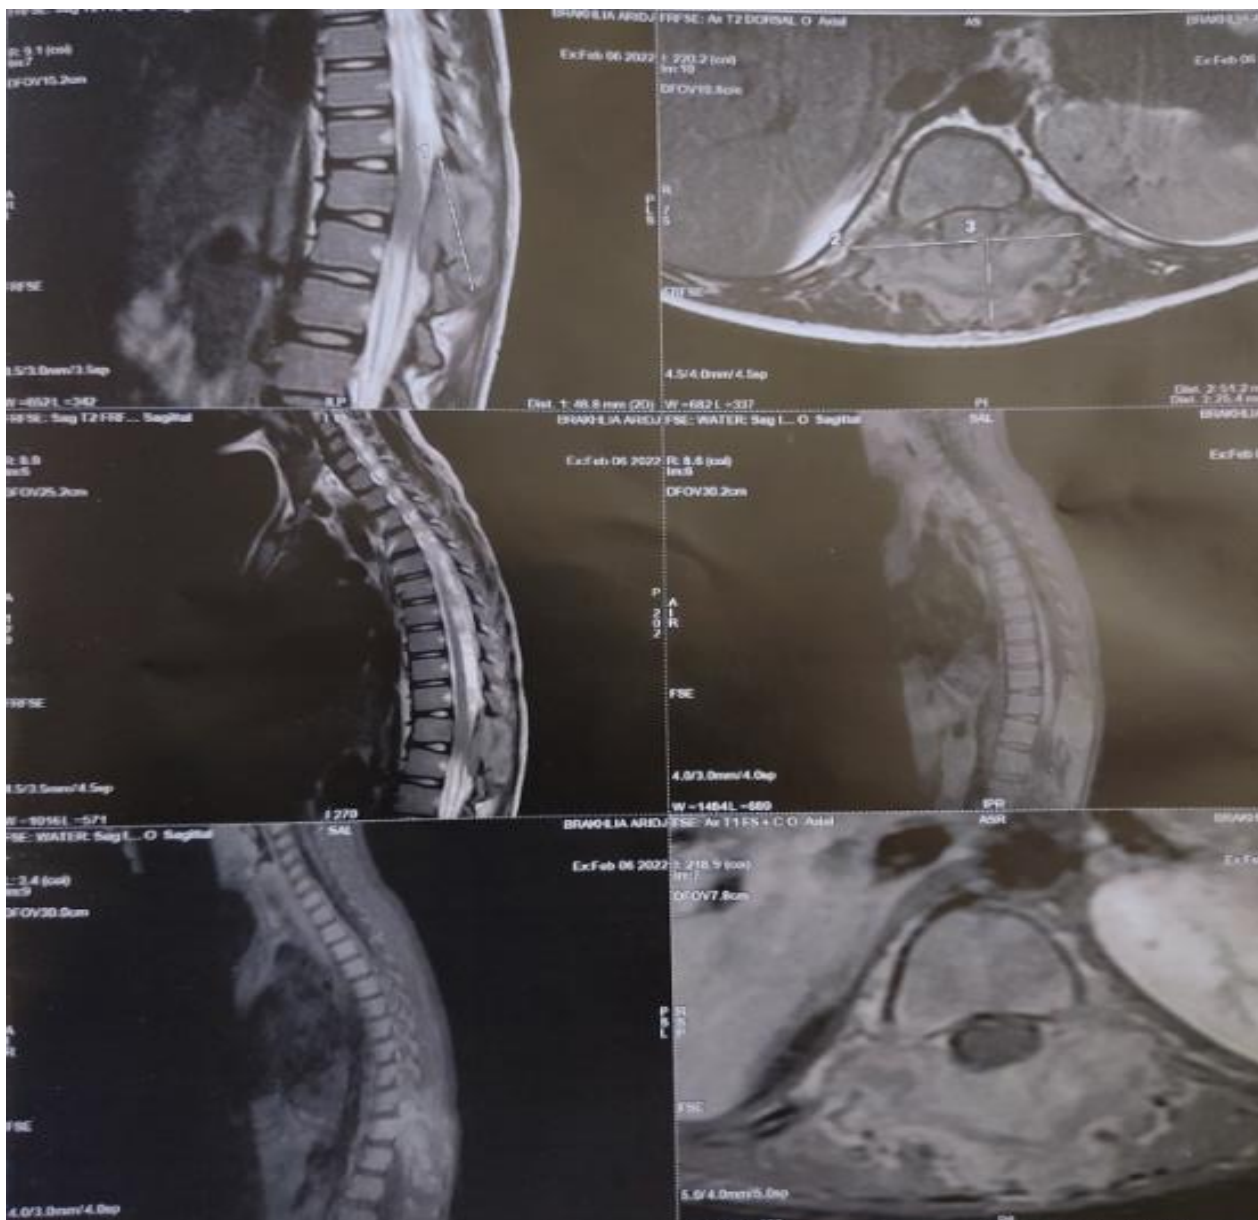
Dorsal MRI in axial and sagittal planes, in T1 and T2 sequences, showing spinal cord compression at the level of TH11
